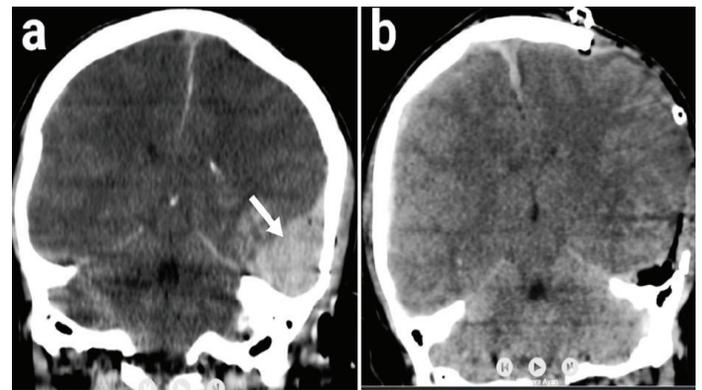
a) Left temporal acute subdural hematoma (white arrow) and linear fracture are seen in coronal non-enhanced cranial CT image. b) Coronal non-enhanced cranial CT image of the same patient after the successful evacuation of hematoma and ipsilateral decompressive craniectomy
